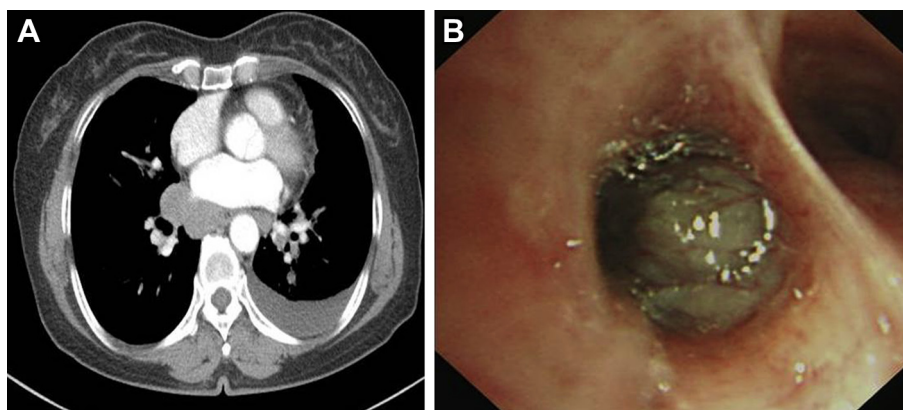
(A) Chest computed tomography reveals mediastinal lymphadenopathy and left pleural effusion. (B) Flexible bronchoscopy demonstrates an endobronchial mass lesion at the anterior basal segmental bronchus of the left lower lobe.
